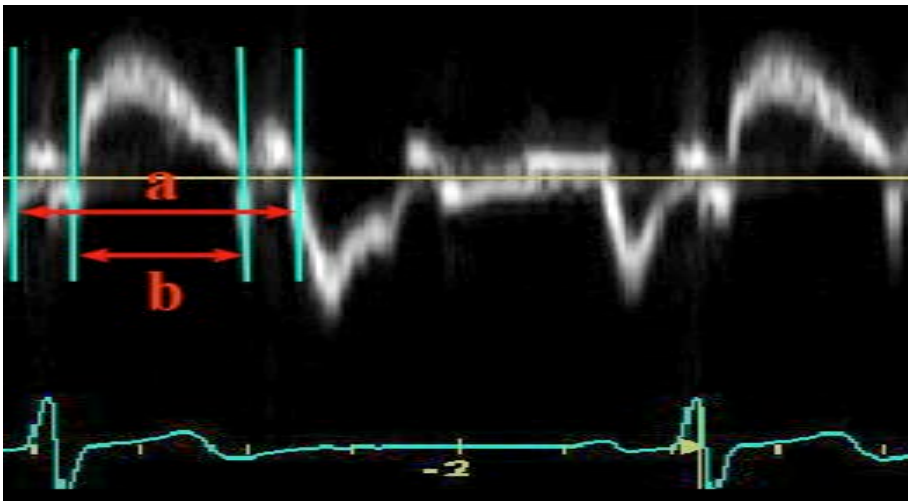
Calculating the RV Myocardial Performance Index (MPI) by tissue Doppler. MPI is the ratio of the sum of the isovolumic contraction and relaxation times (IVCT+IVRT) divided by the right ventricular ejection time (RVET (b)) and is calculated by the equation $MPI=(a-b)/b$.
